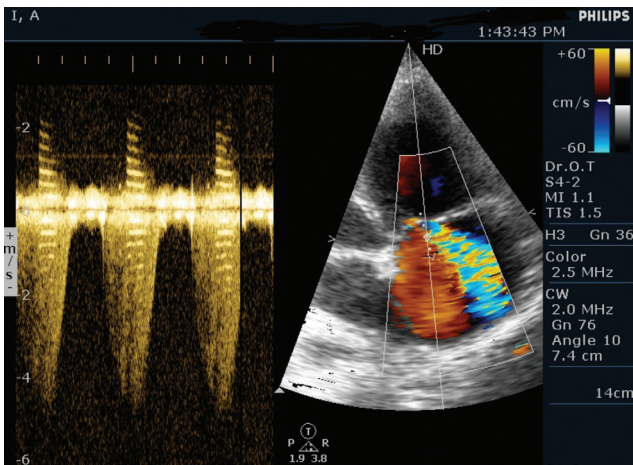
Echocardiography showed severe tricuspid valve insufficiency.
